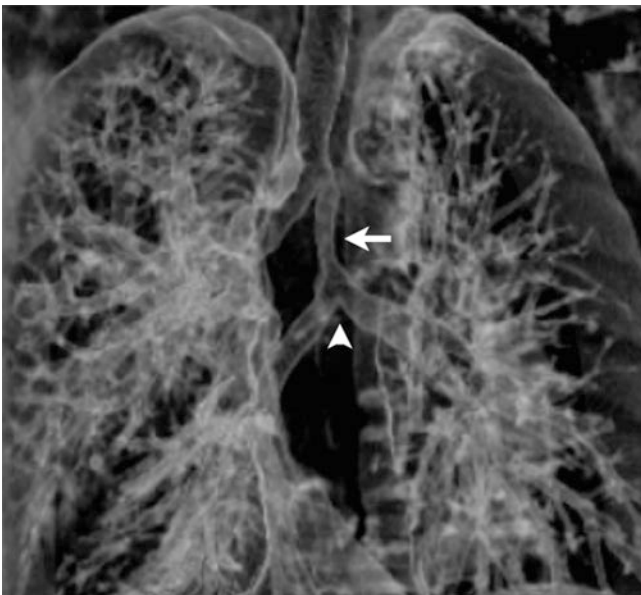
Left pulmonary artery sling in a neonate, CT. 3D volume-rendered reconstruction of the airways. There is a high right bronchus, a narrowed, 'stove-pipe' trachea (arrow) leading to the true bifurcation (arrowhead)
